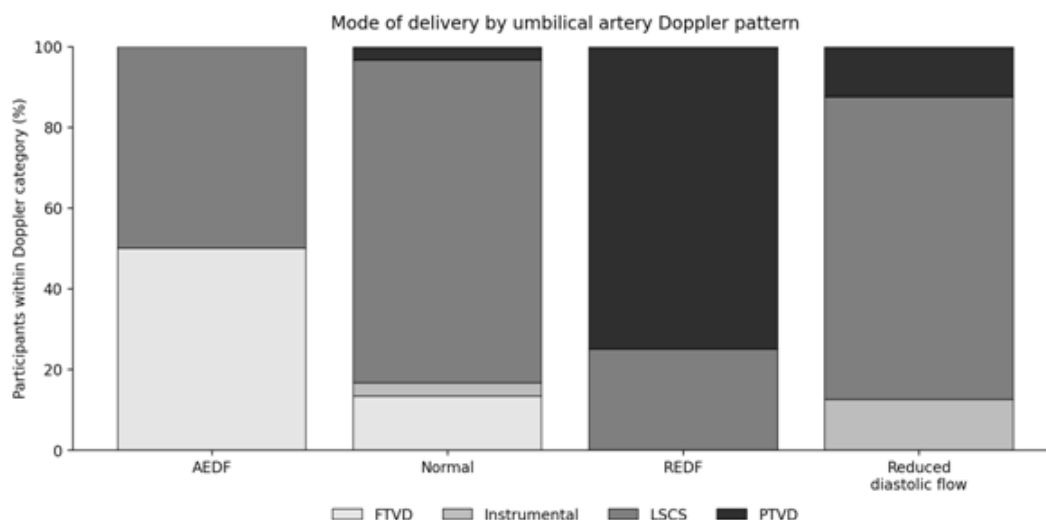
Mode of delivery according to umbilical artery Doppler pattern. Percentages are calculated within each Doppler category
